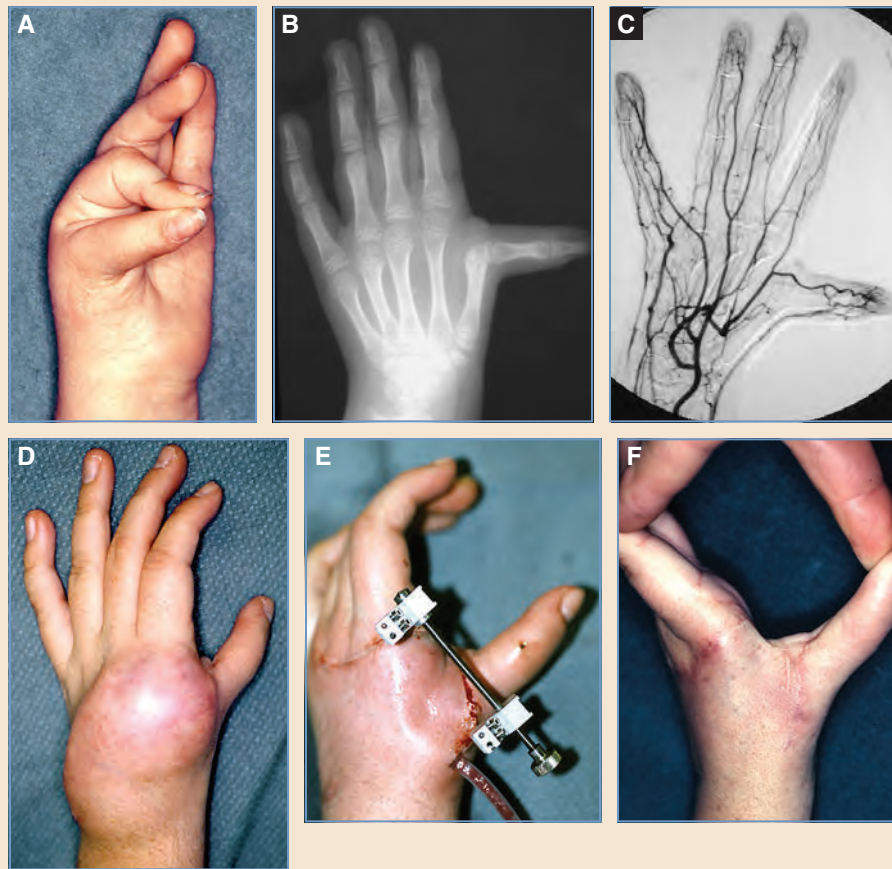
Skin expansion for the first web space. A, This 10-year-old child with type IIIA thumb hypoplasia lacks any stability with pinch as a result of an attenuated ulnar collateral ligament. A Huber transfer performed earlier in childhood pulled the thumb into radial deviation. B, The radiograph shows a 90-degree deviation at the MP joint. C, An inadequate arterial communication between the radial and ulnar sides of the hand ruled out a distally based forearm flap reconstruction of the first web space. D, Dorsal skin has been expanded over a 4-week period. E, This skin was advanced to provide adequate coverage. At the same time, the ulnar collateral ligament was reconstructed with both local tissue and a free tendon graft. F, Following reconstruction, the patient has a stable MP joint and a wide first web space lined by full-thickness tissue.
